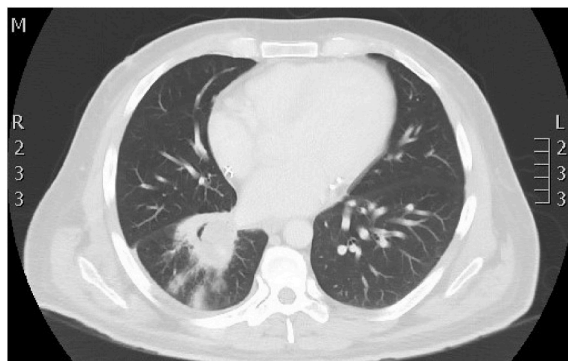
Chest CT demonstrating a right lower lobe cavitating mass (3.5 × 2.9 cm).
